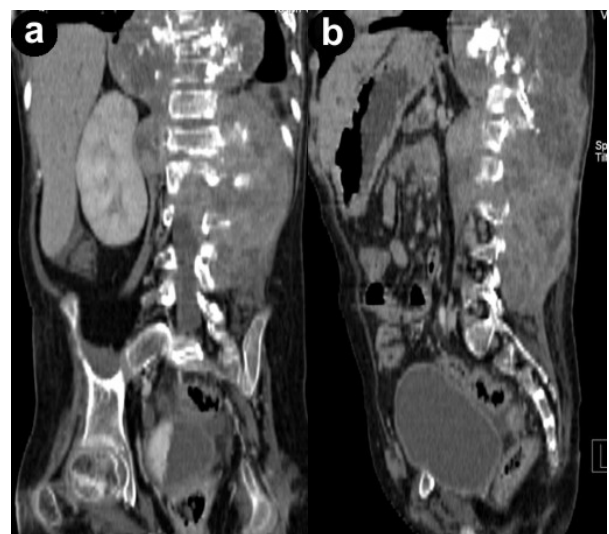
On abdominal CT using heterogeneous contrast enhancement, a huge mass containing necrotic and calcified areas and causing bone destruction is seen between thoracic vertebra 7 and sacral vertebra 1 involving both the vertebrae and the paravertebral soft-tissue.
